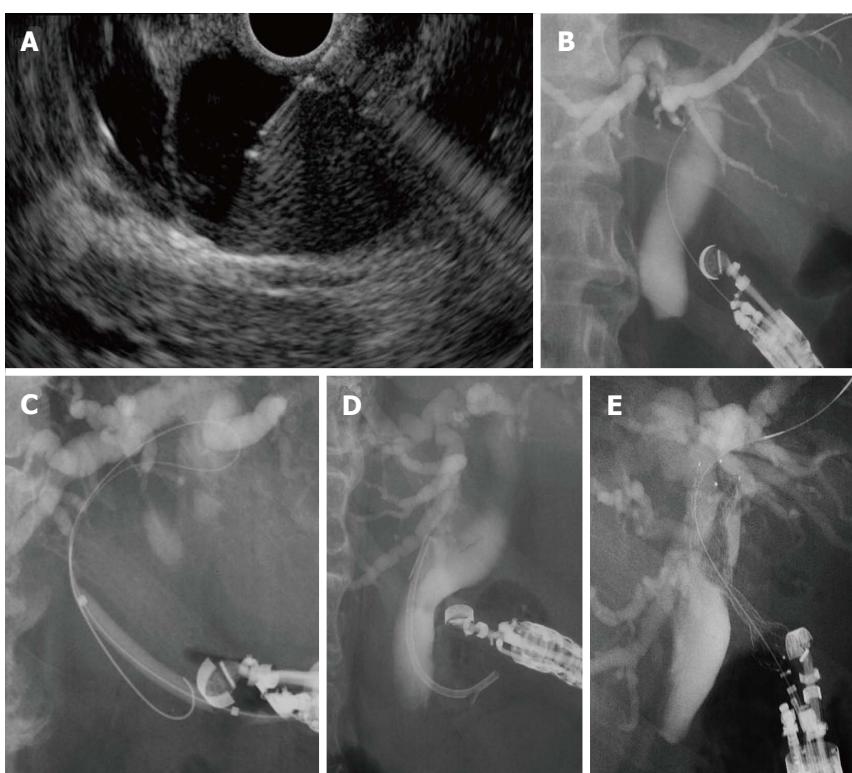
Technique of endoscopic ultrasound-guided choledochoduodenostomy. A: The extrahepatic bile duct is punctured by a 19-gauge needle under EUS guidance; B: After contrast medium is injected, a guidewire is inserted; C: The puncture tract is dilated with a tapered catheter, a balloon dilator, and/or ES Dilator; D and E: A plastic stent (D) or a metal stent is deployed at the puncture site (E). EUS: Endoscopic ultrasound.
